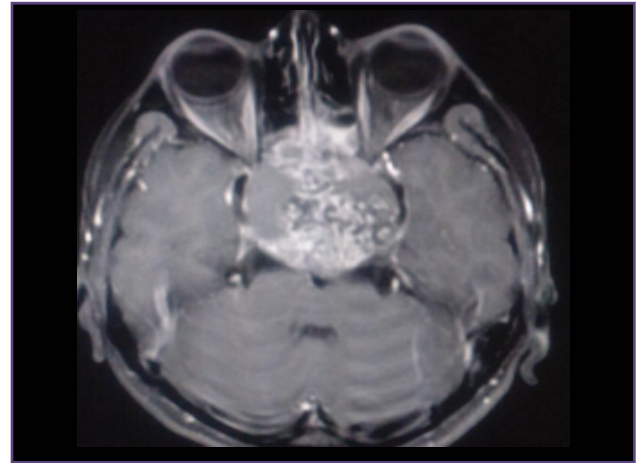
T2 weighted coronal MRI image shows a solid-cystic intensely enhancing sellar mass (craniopharyngioma).
